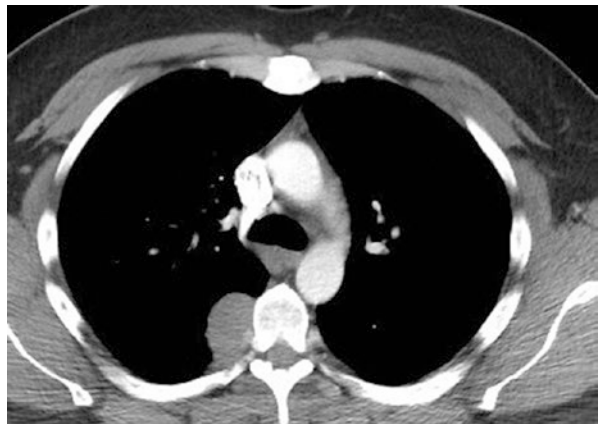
Computed tomography of posterior mediastinal schwannoma
